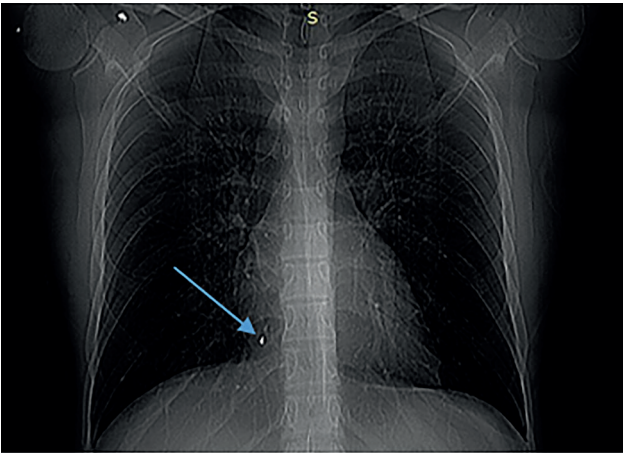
Computed tomography showing a foreign body (indicated by a blue arrow).
